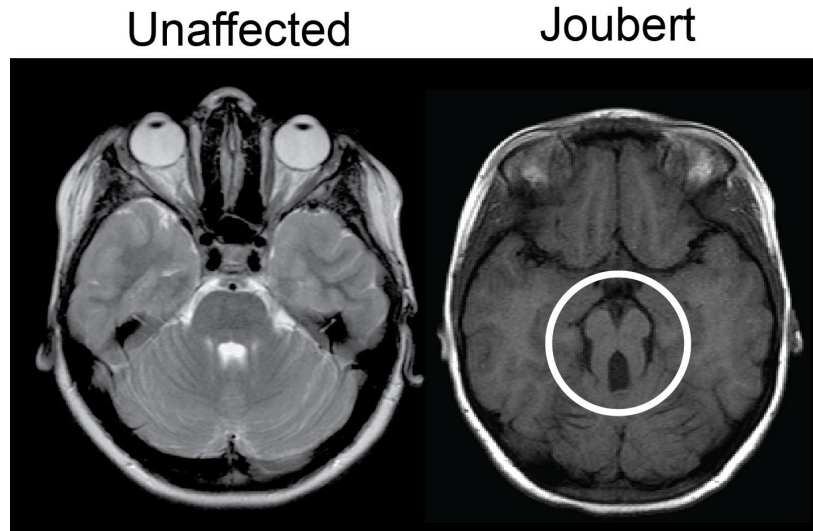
The molar tooth sign. Axial magnetic resonance imaging of an unaffected individual (left) and an individual with Joubert syndrome (right), showing the molar tooth sign, circled in white.
